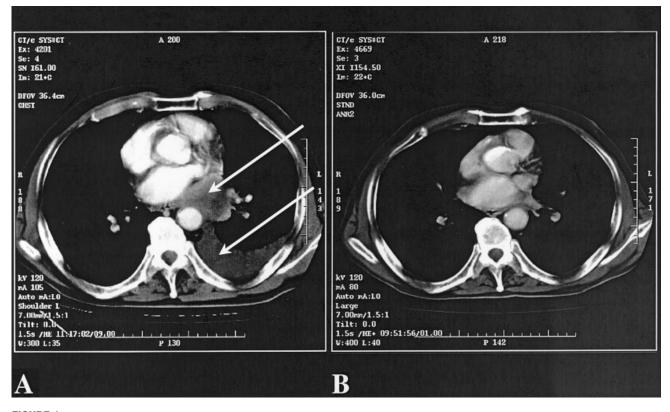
(A) Pretreatment and (B) posttreatment chest computed tomography scans from a male patient age 66 years with lung metastases from renal cell carcinoma; arrows indicate pulmonary metastatic disease sites and pleural effusion. Treatment yielded a complete response in the lung, with extrapulmonary disease persisting. According to the Response Evaluation Criteria in Solid Tumors, this patient had achieved a global partial response.
